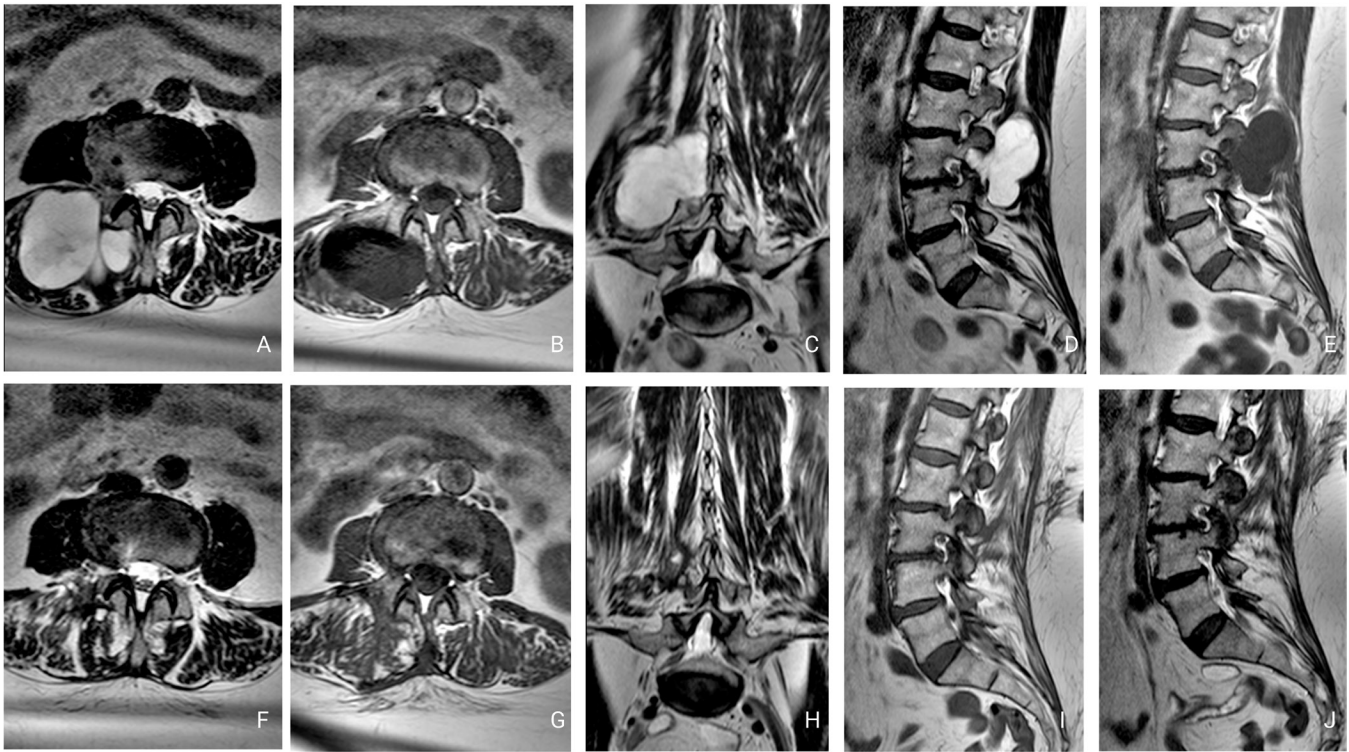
Pre- and postoperative lumbar magnetic resonance images (MRI). Preoperative imaging revealed a lobulated, well-defined lesion with a cystic appearance, measuring 5 × 5.4 × 5.5 cm, at the L3 to L4 level. Postoperative MRI showed complete resection with minimal fascia and paraspinous musculature transgression. (A) Preoperative axial T2-weighted image showed a hyperintense lesion. (B) Preoperative axial T1-weighted image showed a hypointense lesion. (C) Preoperative coronal T2-weighted image. (D) Preoperative sagittal T2-weighted image. (E) Preoperative sagittal T1-weighted image. (F) Postoperative axial T2-weighted image. (G) Postoperative axial T1-weighted image. (H) Postoperative coronal T2-weighted image. (I) Postoperative sagittal T2-weighted image. (J) Postoperative sagittal T1-weighted image.
